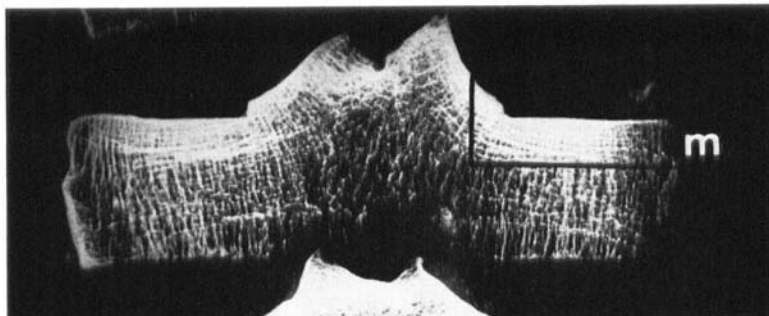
Radiograph of a 5 mm thick slice from normal tibial condyles (*m* = medial). The demarcated zone was used for biochemical assay.
